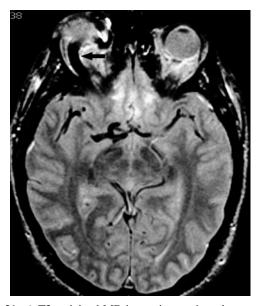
A T2-weighted MR image in a patient shows a rightsided dural CCF. Note the enlarged SOV (*arrow*).
